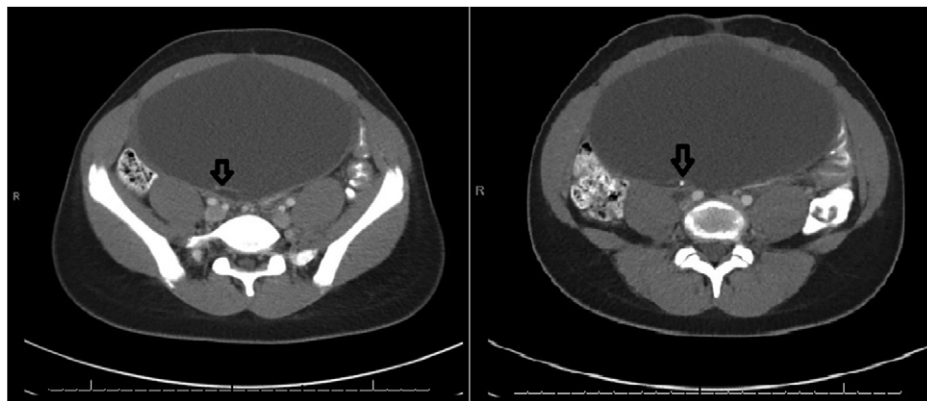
CT of the abdomen (axial view) showing fat in the right side and calcification in the left side as indicated by arrows.
